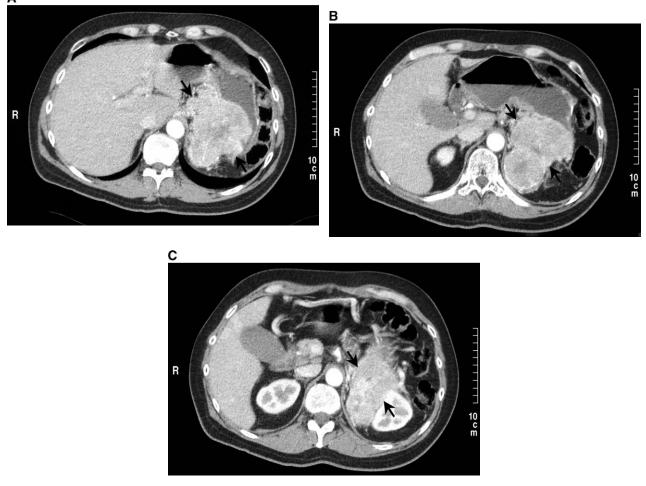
Computer tomography scan performed before the resection of the large left upper retroperitoneal mass (*arrows*) in patient 2. Note the hypervascularity of the lesion and the large collaterals. The vascularity washes out in late phase. From a radiographic standpoint, the tumor appears consistent with (1) adrenal carcinoma, (2) nonfunctioning islet cell tumor, (3) retroperitoneal sarcoma, or (4) gastrointestinal stromal tumor.
